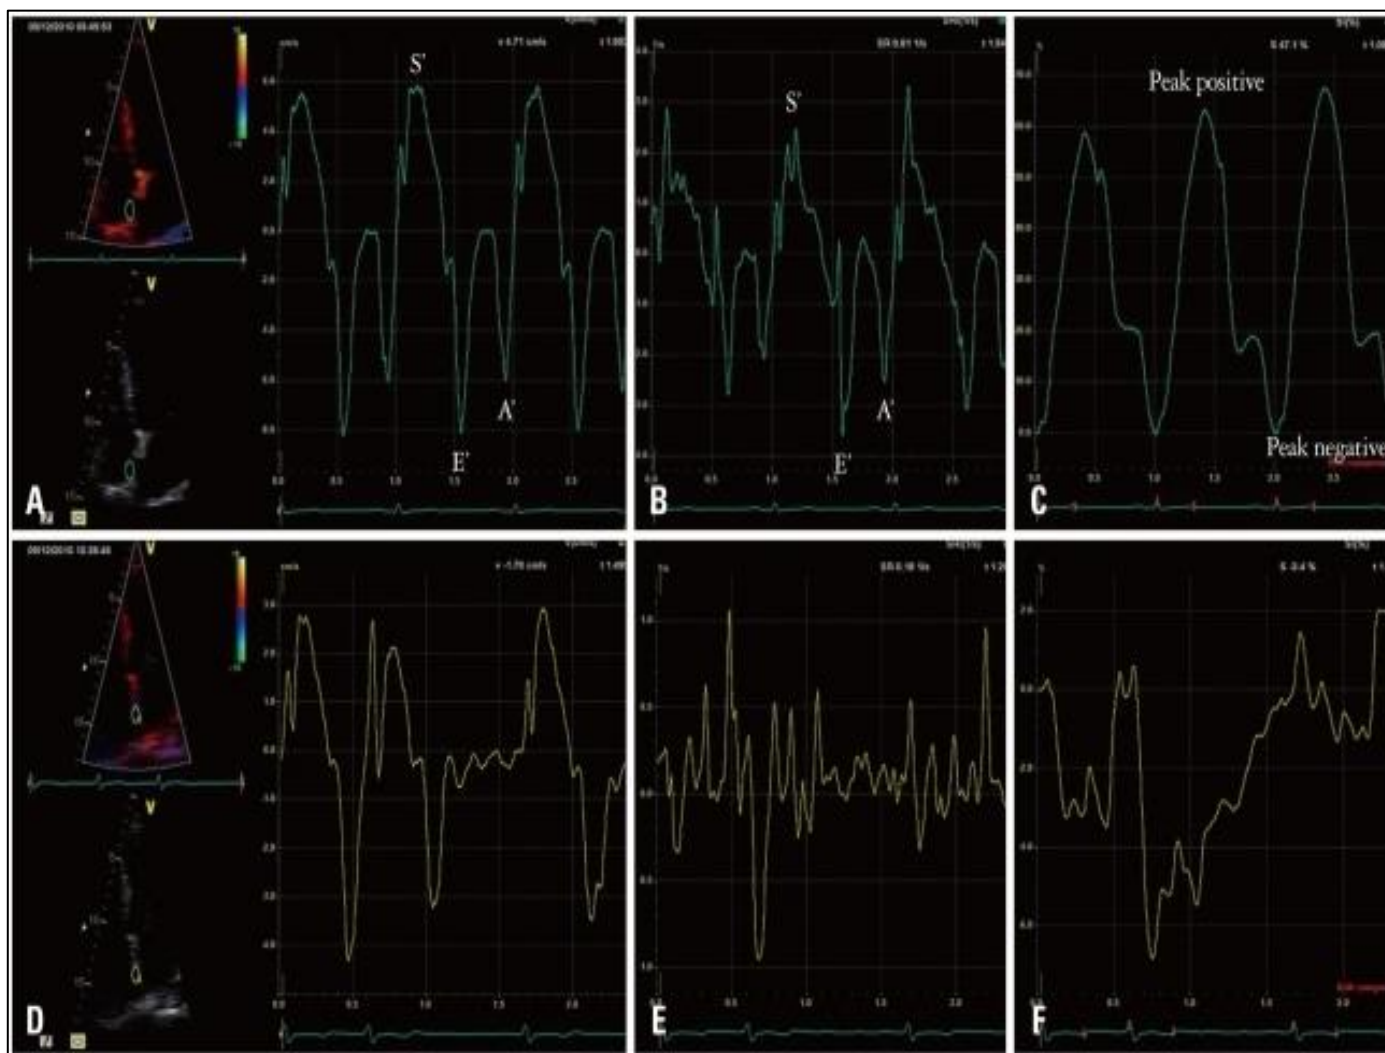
Representative Velocity Flutter of the Left Atrial Myocardium Using Strain Rate (SR), Strain Curves, and Tissue Doppler Imaging (TDI) from Patients with Atrial Fibrillation (D, E, and F, respectively) and Normal Cases (A, B, and C). The Interatrial Septum's Center was where the Sample Volume was Placed. Atrial Contraction did not Cause a Decrease in SR in AF Patients; However, the AF Wave Caused a Small Amplitude Phase Noise to be Recorded. It was Shown that the LA Mechanical Function is Decreased in AF, which is Characterized by Decreased S' and/or E' Waves in the Absence of End-Diastolic A' Waves, using TDI-Derived Velocity and SR Parameters. A' Wave is the Late Diastolic Wave, E' Wave is the Early Diastolic Wave, and S' Wave is the Ventricular Contraction Wave.
